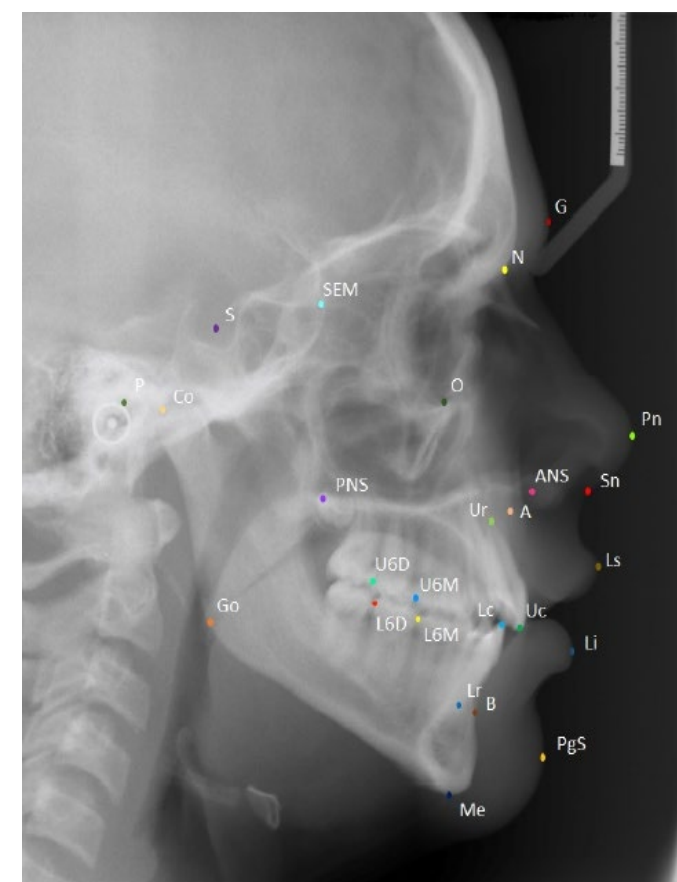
A sample cephalometric X-ray showing the 27 anatomical landmarks that are typically plotted on lateral cephalograms for orthodontic treatment.
